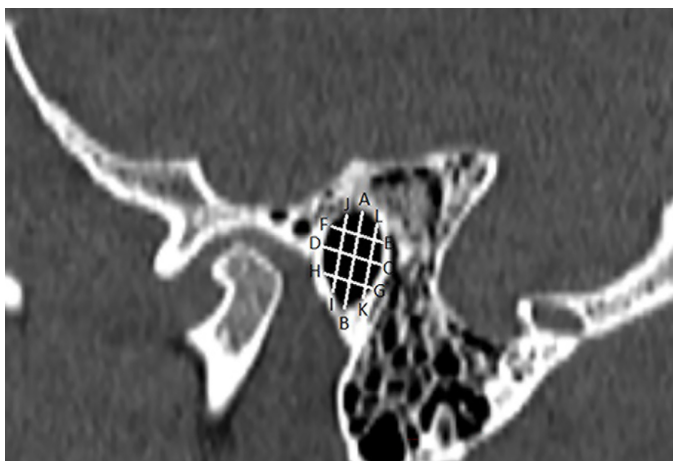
Reconstructed CT slice shows the points of the "mesh" technique: AB line for maxSI, CD line for midAP, EF line for midS, GH line for midI, IJ line for midA, KL line for midP.
